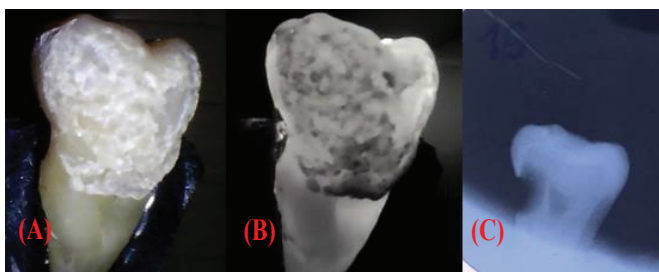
Sample 10 under visible light (A), NIR light (B), and X-rays (C).
